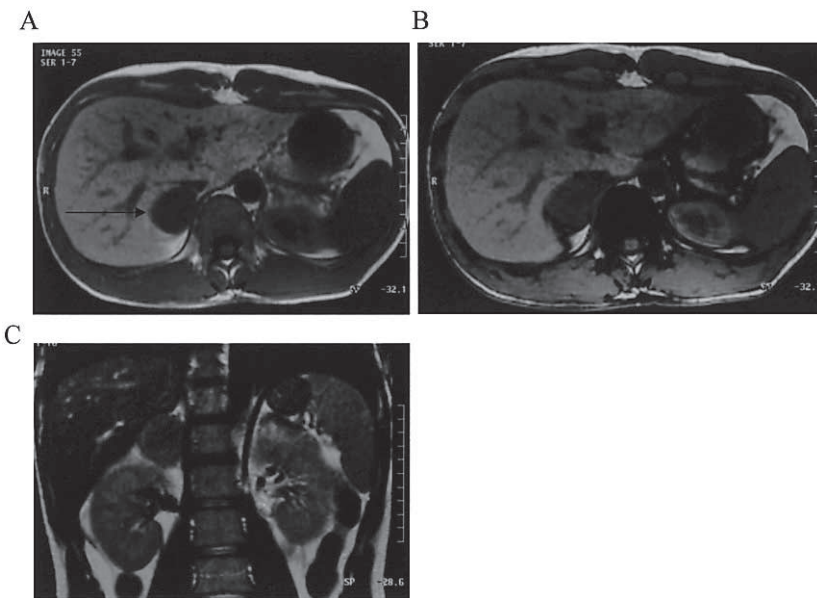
A: axial image (in-phase), B: axial image (out-of-phase), C: coronal image (in-phase). Abdominal T1-weighted MRI showed homogeneous hypo-intensity mass in the right adrenal gland both in in-phase and out-of-phase studies (). The intensity of the right adrenal gland was not significantly different from that of left one.
